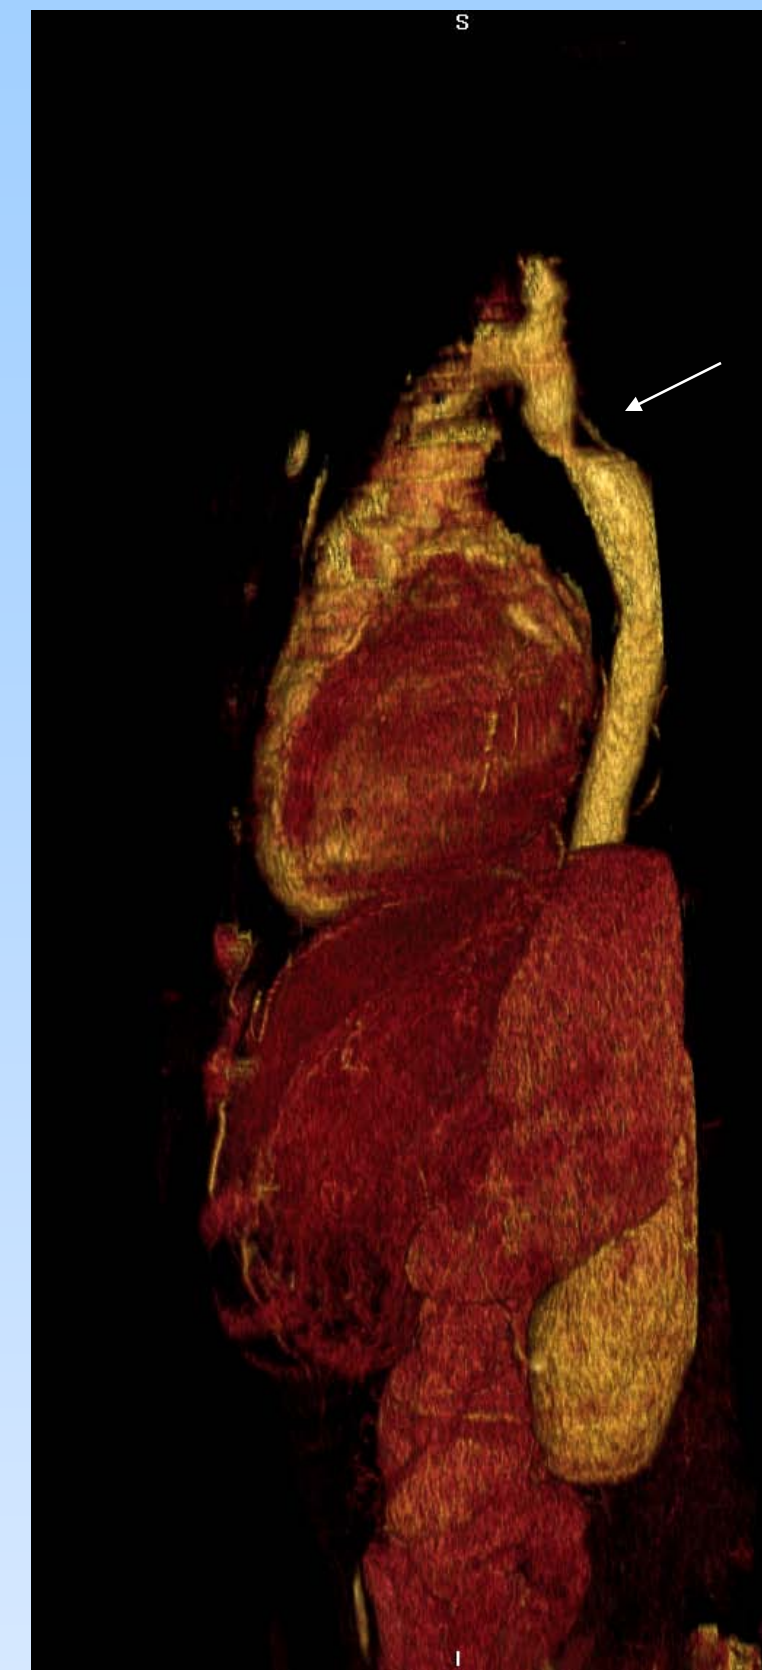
Lateral view of 3-D reconstruction of CTA showing coarctation of aorta distal to left subclavian
